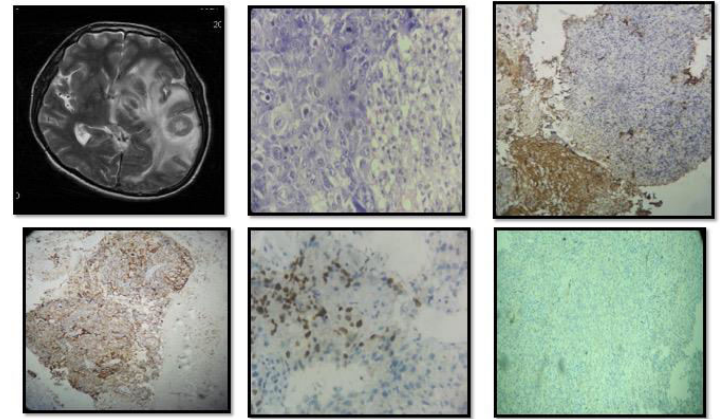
Metastasis- A) MRI showing space occupying lesion in Parietal lobe, B) H& E Section shows metastatic tumour deposits. On IHC C) GFAP positive in brain tissue D) CK positive E) P 63positive F) TTF-1 negative
